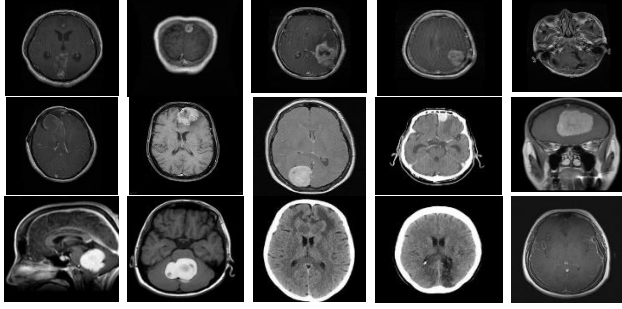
Sample MRI scans from the dataset.
